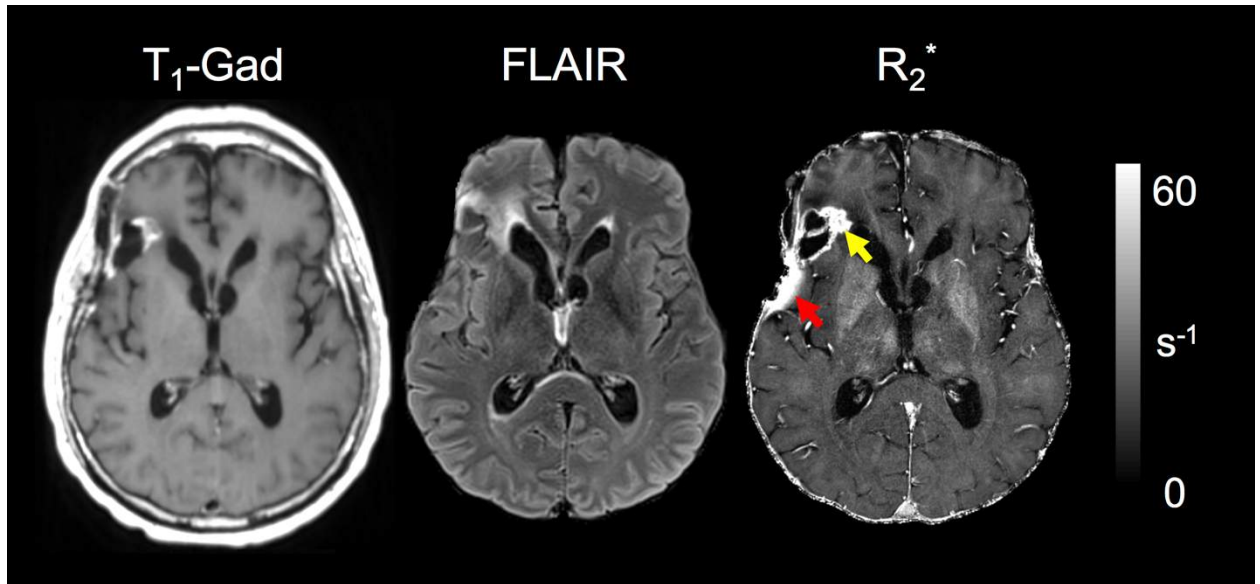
Patient 7 shows gadolinium enhancement on T_1 (A) and FLAIR enhancement (B) in the posterior right frontal lobe near the right frontal horn.
